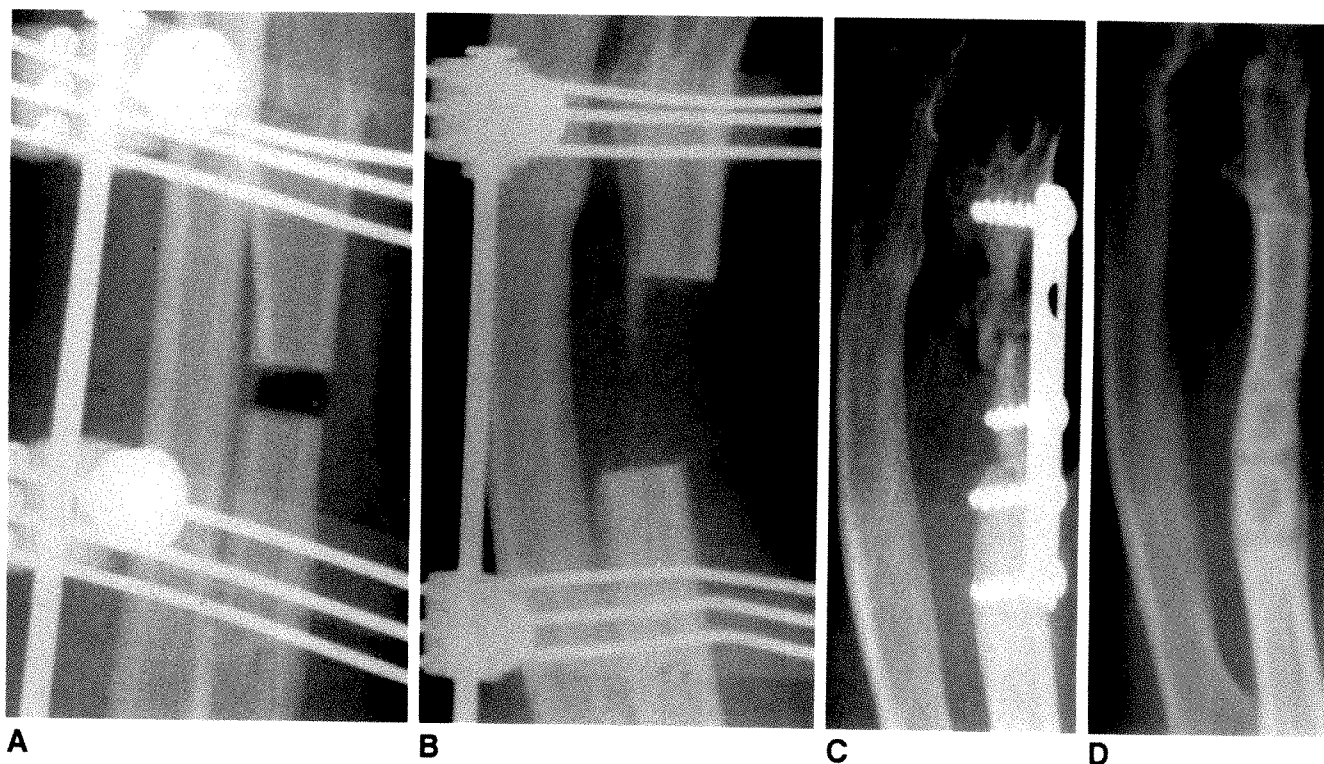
Serial radiographs show application of Wagner technique to lengthen a hypoplastic ulna.
